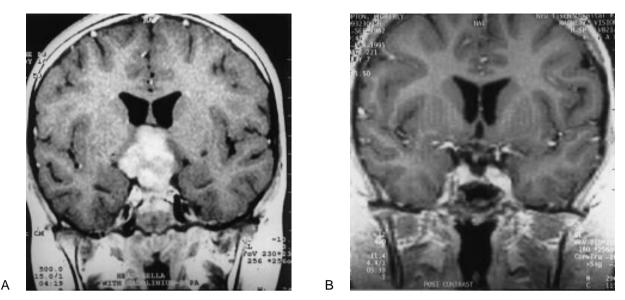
T1-weighted coronal gadolinium-enhanced MRI of a suprasellar NGGCT at diagnosis (a), and showing a complete response after 4 cycles of neoadjuvant chemotherapy (b).
